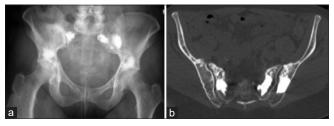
Anterior posterior radiograph (a) and axial computed tomography (b) showing bilateral sacroplasty and acetabuloplasty and left ilioplasty.
